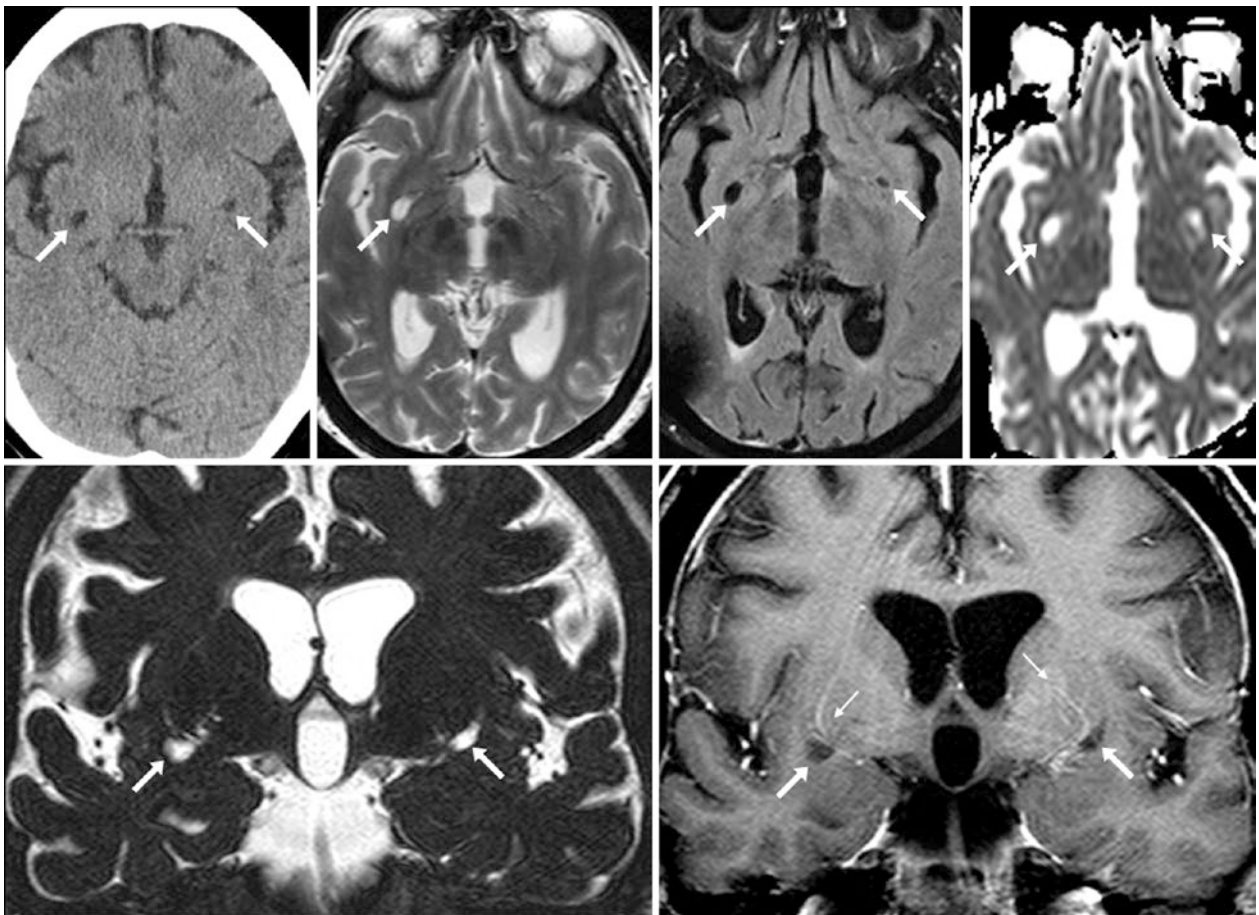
A 46 year old had dilated PVSs bilaterally (*arrows*) within the inferior putamina on axial NECT (*top left*), T2WI (*top, left middle*), FLAIR (*top, right middle*), and an ADC map (*top right*). The PVSs suppress with CSF on FLAIR and are bright on ADC maps. Thin-section (0.8 mm) balanced echo three-dimensional T2WI (*bottom left*)
